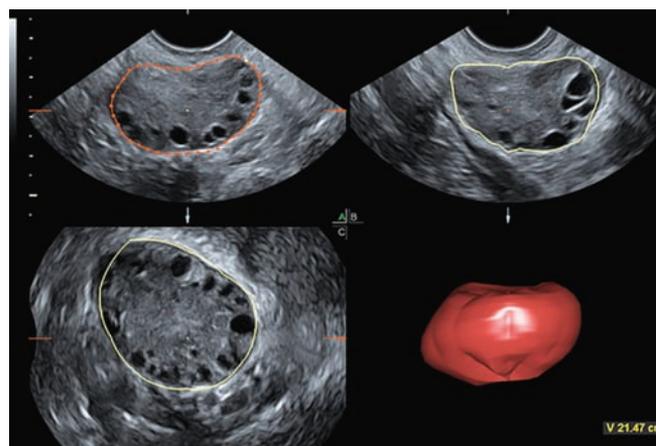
Three-dimensional ultrasound with VOCAL to calculate the ovarian volume
